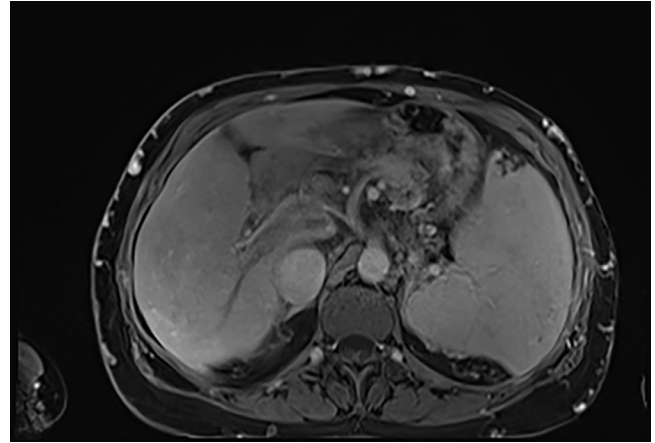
Postcontrast MRI shows the mass occluding the portal vein and encasing the common hepatic artery and common bile duct without upstream dilatation.
